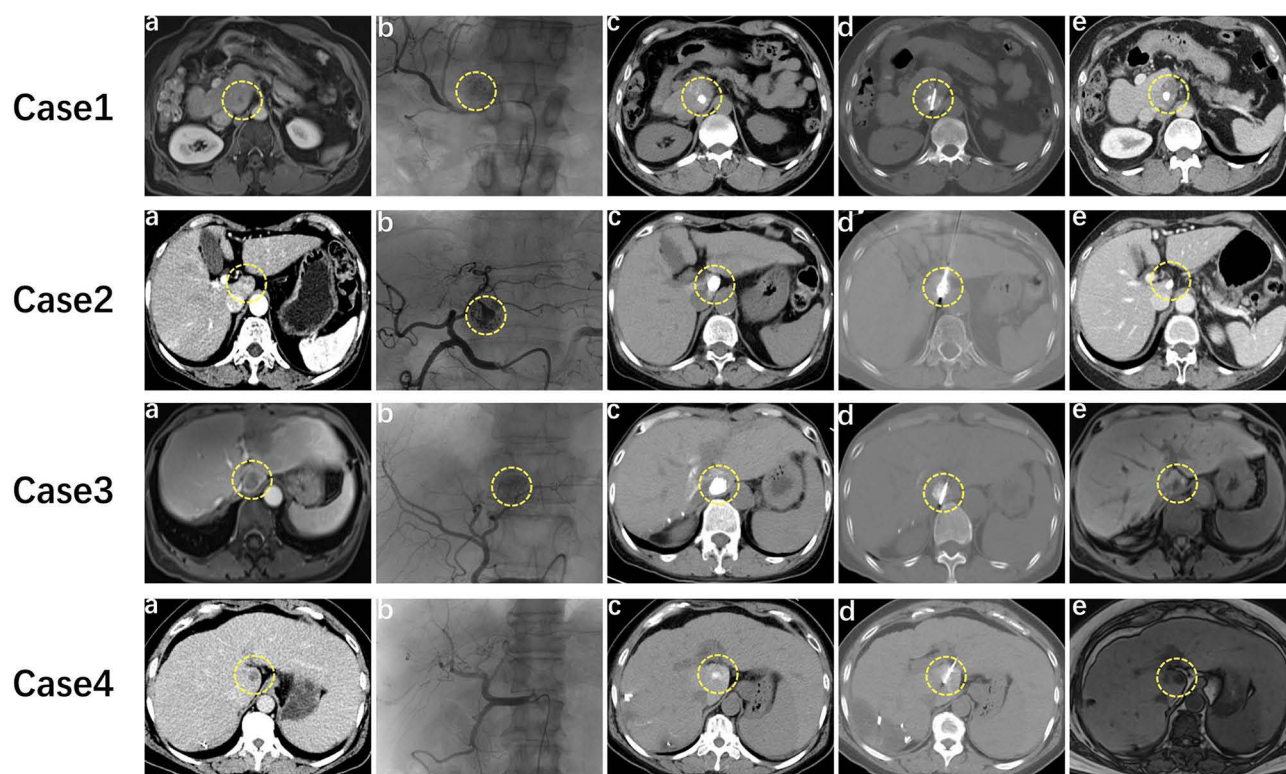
Imaging findings during combined TACE and MWA for Spiegel lobe HCC in four patients. (a) Pre-TACE lesion localization. (b) The image shows a dense shadow caused by the deposition of TACE contrast medium during the operation. In Case 4, the Spiegel lobe lesion could not be clearly seen on hepatic arteriography and therefore has not been marked in the figure. (c) Pre-ablation CT scan with the tumor delineated by the deposited iodinated oil. (d) Intraoperative plain CT scan for MWA, demonstrating precise needle placement at the lesion center. (e) One-month follow-up imaging confirms treatment response, with the ablation zone showing no enhancement and complete tumor coverage. The circle denotes the lesion location.
